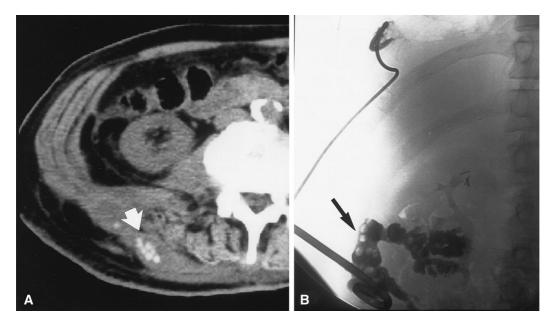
A Noncontrast CT shows multiple calcifications in the superficial soft tissues of the right flank (*arrow*). Note surrounding inflammatory soft tissue changes. B Fluoroscopic image from sinogram during percutaneous removal of flank gallstones shows multiple filling defects within the cavity (*arrow*), consistent with retained gallstones.
